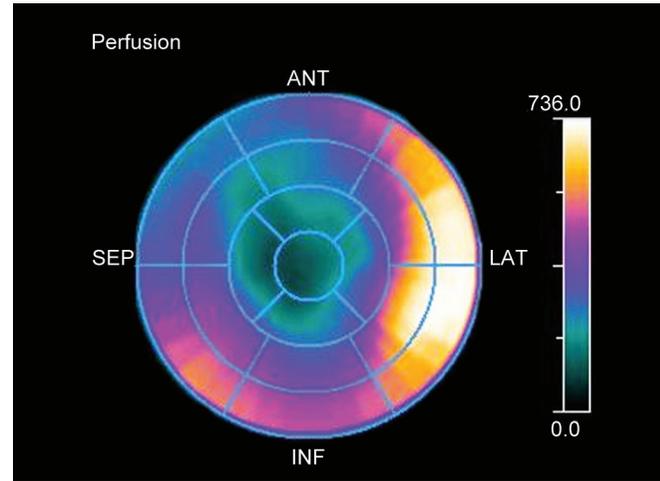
NTG SPECT depiction of nonviable myocardium in LAD territory
